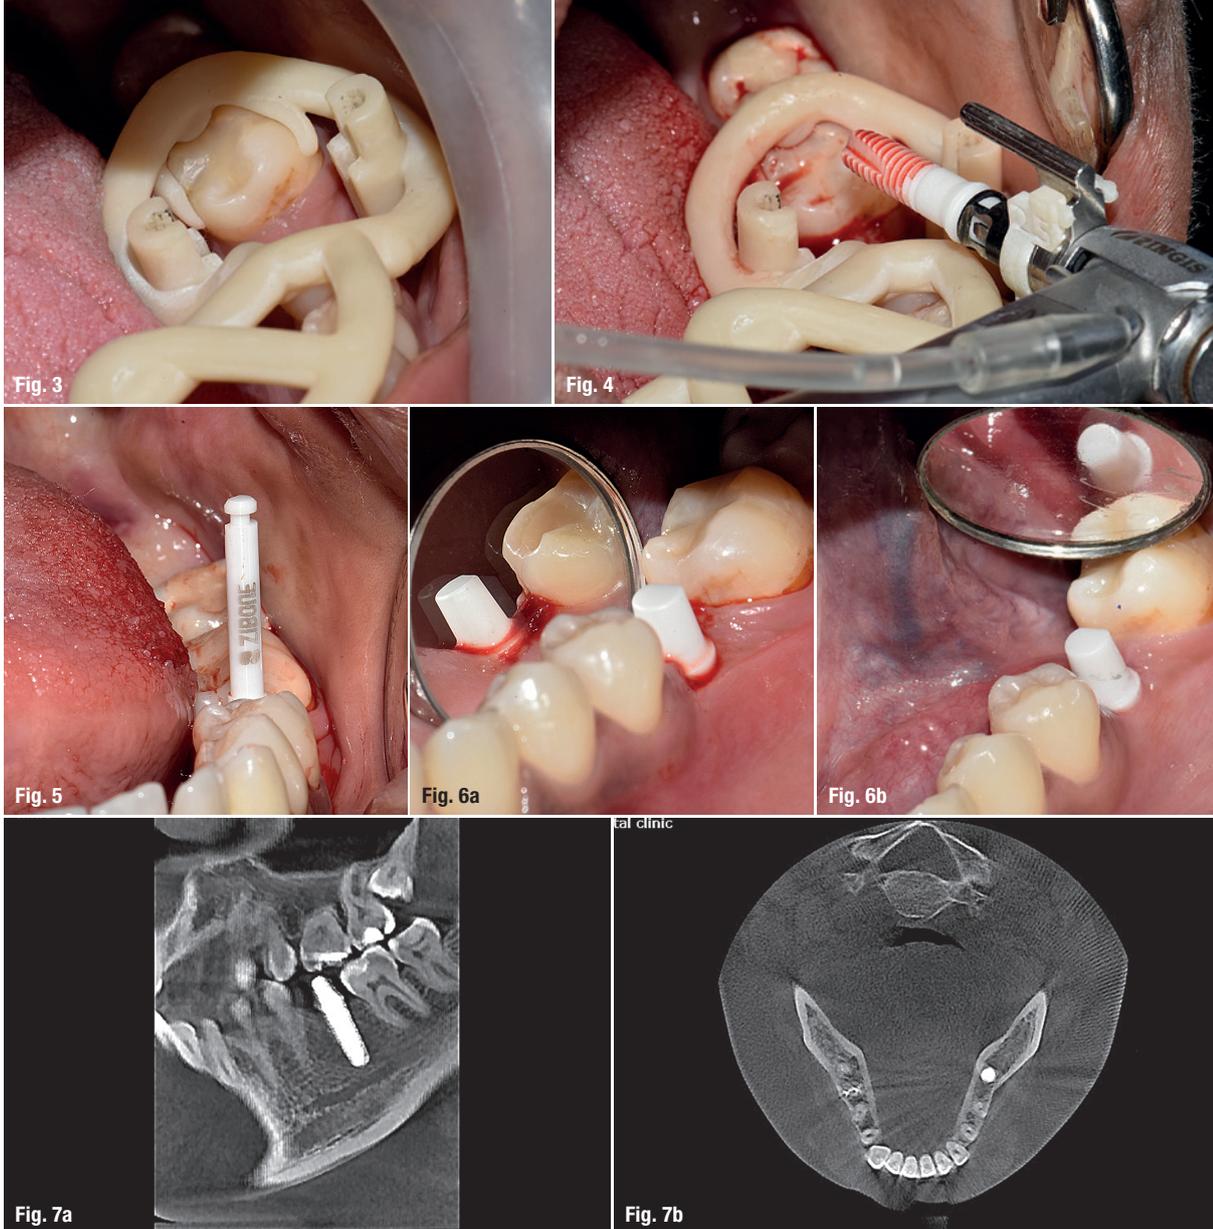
Stabilisation of guide. Fig. 4: Implant placement. Fig. 5: Ideal position of implant. Figs. 6a & b: Immediately post-op (a); seven days post-op (b). Figs. 7a & b: CBCT scan.
